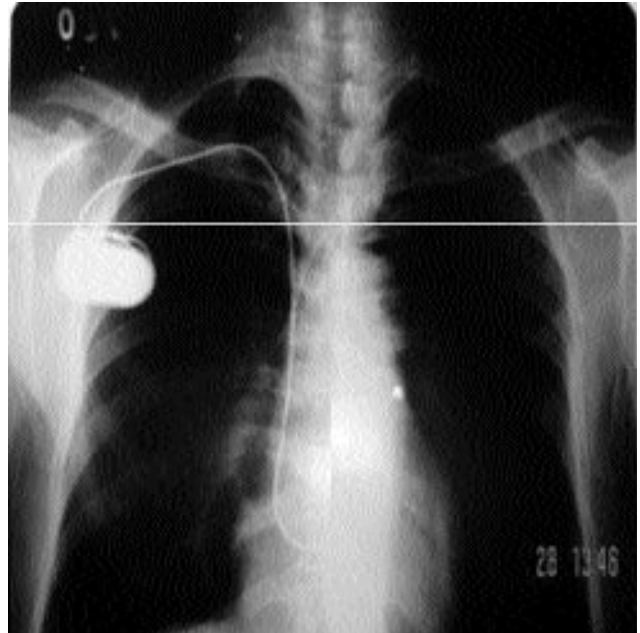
Chest roentgenogram showing bilateral subclavian transvenous pacemaker wires and a subcutaneous pacemaker.
